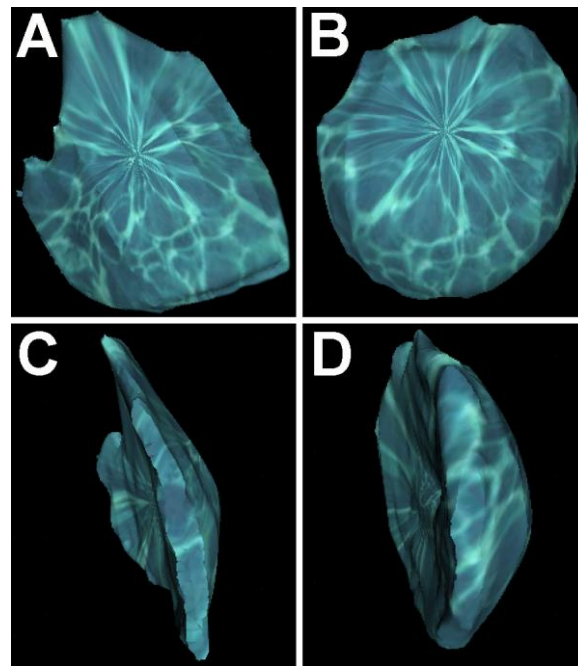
Volume-rendered 3D reconstructed images of breasts segmented from a computer tomographic (CT) scan using Osirix software (Pixmeo, Geneva, Switzerland), from which volume differential can be calculated. A: anterior view of the right breast; B: anterior view of the left breast; C: lateral view of the right breast; D: lateral view of the left breast. Reproduced with permission from Chae *et al* (35).
